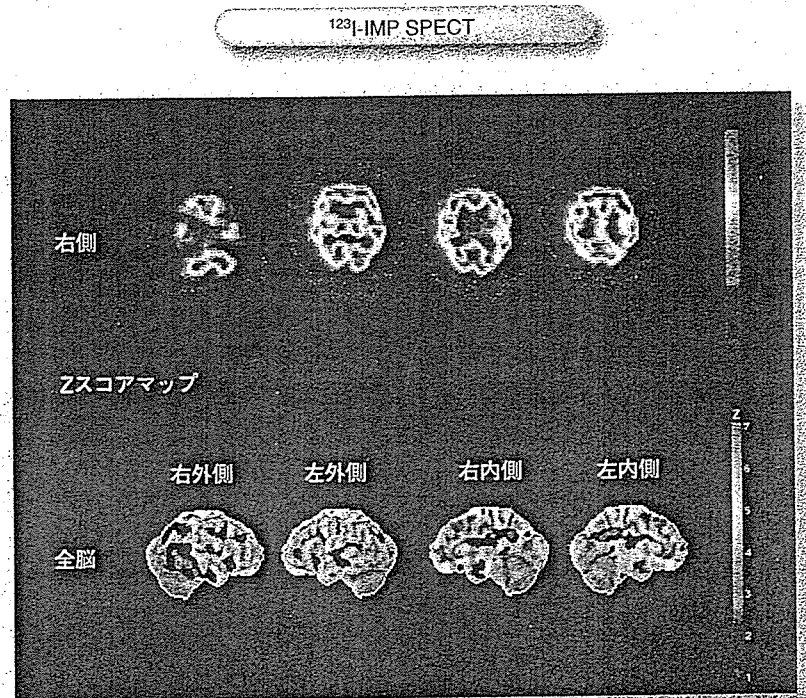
Alzheimer病の¹²³I-IMP SPECTイメージを3D-DDPで解析したZスコアマップ
